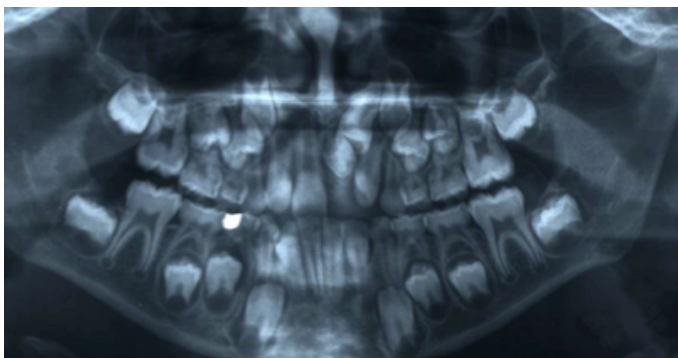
Panoramic conventional radiograph showing a supernumerary tooth associated to the impacted left central incisor.
